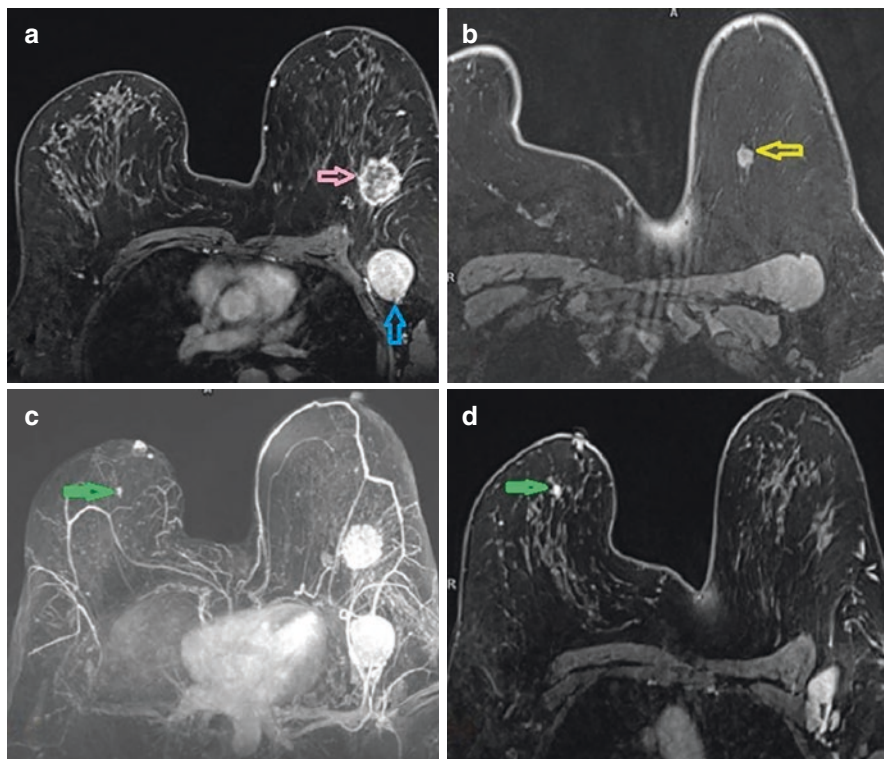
Patient presented with lump in the left breast. Post contrast T1 Weighted axial fat sat images shows (a) an irregular heterogeneously enhancing mass (light pink arrow) in the outer half of left breast with a grossly enlarged ipsilateral node (blue arrow) [HPE: IDC]. (b) A small irregular enhancing nodule (yellow arrow) was seen in the upper inner quadrant of ipsilateral breast which was more than 4 cm apart from index lesion. It was biopsied on second look ultrasound and HPE showed IDC. MIP (c) and axial post contrast T1 weighted fat sat (d) images show tiny irregular enhancing focus (green arrow) in the retro areolar region of right (contralateral) breast. Patient underwent MRI guided vacuum assisted breast biopsy for the tiny right breast focus and HPE showed benign breast change
